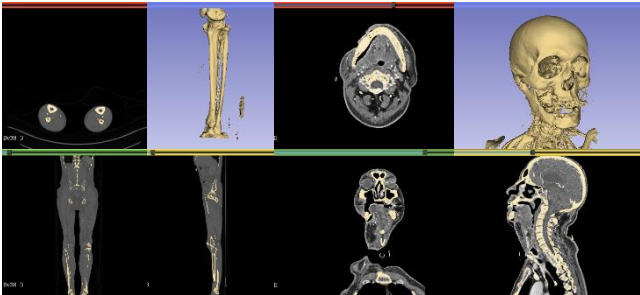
Segmentation of CT scans and resulting models, before post-processing
